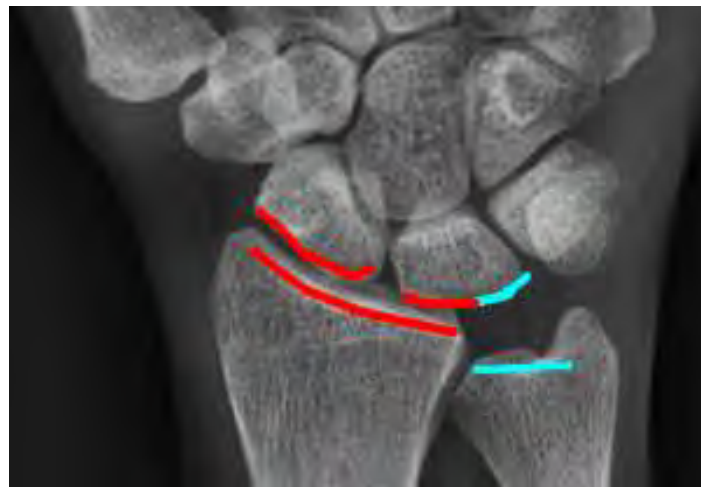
Radiograph of the wrist showing negative ulnar variance, namely, a "short" ulna that does not reach as far distally as the radius. The blue lines show the area where the ulna does not make contact with the lunate. This loss of contact creates greater pressure from the radius, which is thought to be the cause of the disease. (The articulation between the radius and the scaphoid and lunate is shown in red.)
